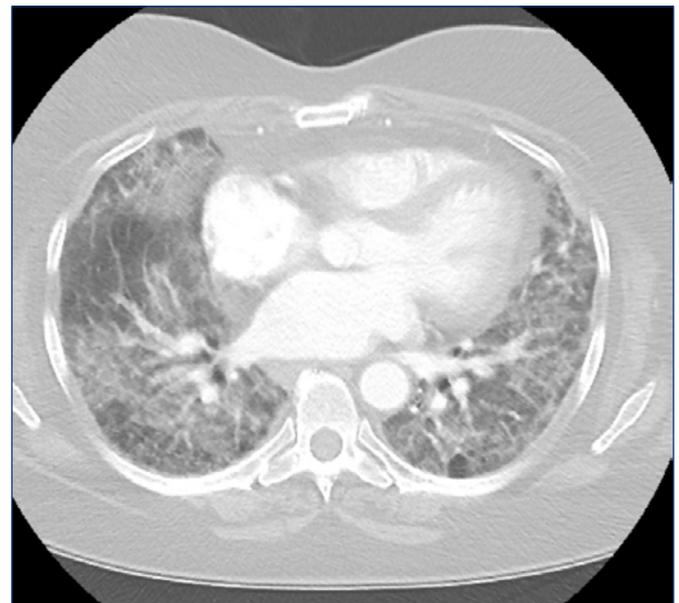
A high resolution chest CT showed diffuse ground-glass opacities, extensive sub-pleural reticulation, traction bronchiectasis, and areas of honeycombing.
